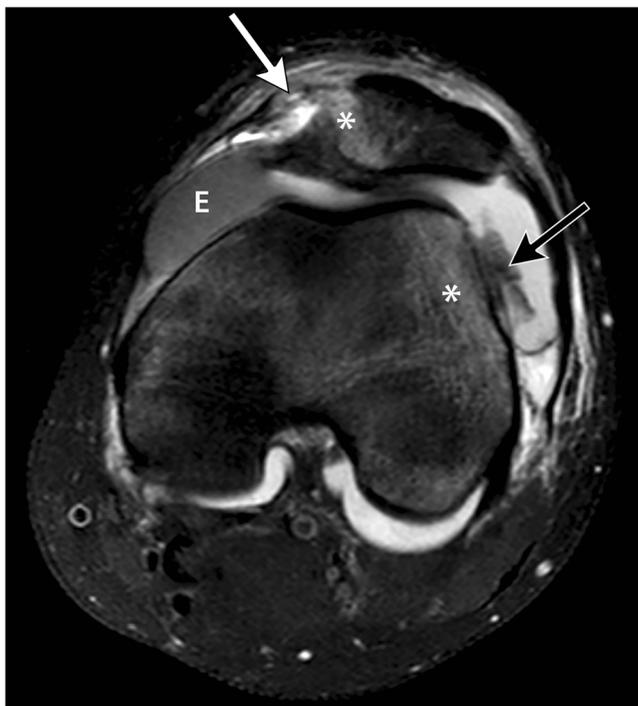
13-year-old girl soccer player with transient patellar dislocation. Axial proton density fat-saturated MR image through the knee demonstrates a full-thickness tear of the medial patellar retinacular structures (*white arrow*), bone contusions/edema in the medial patella and lateral femoral condyle (*asterisks*), cartilage fragments/intra-articular bodies (*black arrow*) from a donor site in the patella (not included on this image), and a large, heterogeneous joint effusion (E)
